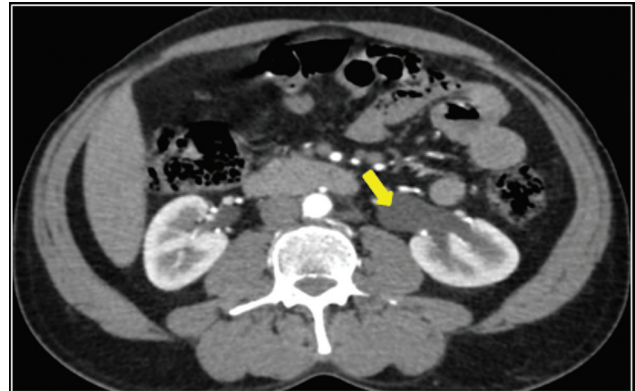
CECT-KUB (corticomedullary phase) axial section at the level of renal pelvis showing left HUN. CECT-KUB, contrast-enhanced computed tomography kidney, ureter, and bladder; HUN, hydroureteronephrosis.
